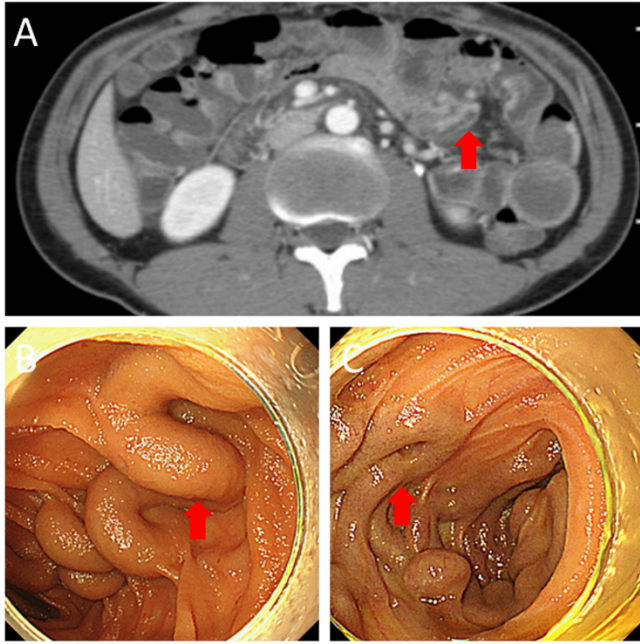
Small intestinal venous ectasias. A. Abdominal contrast-enhanced computed tomography showed small intestinal venous ectasias. B. The oral approach enteroscopy showed obvious jejunum venous ectasias. C. The anal approach enteroscopy showed obvious ileum venous ectasias.
